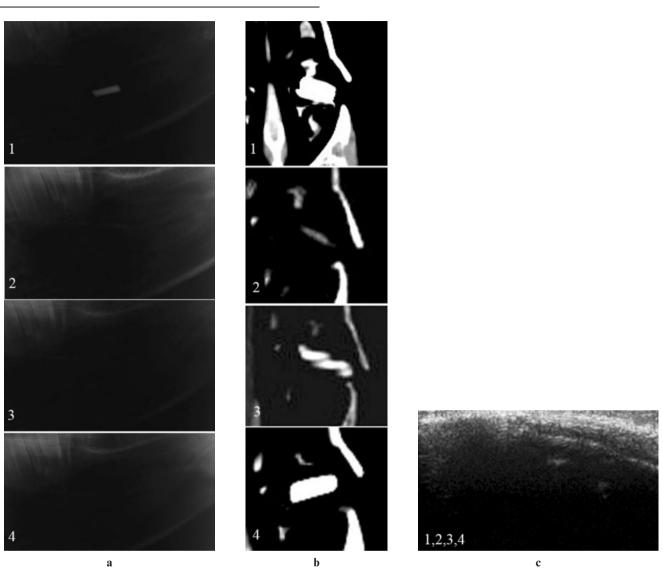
Visibility of foreign body in air. (a) Conventional plain radiography. (b) CT. (c) Ultrasonography. 1, metal; 2, dry wood; 3, graphite; 4, Bakelite. Note that it is not possible to evaluate the foreign bodies' visibility in air with ultrasonography. For this reason, only one figure was submitted to represent all bodies.
